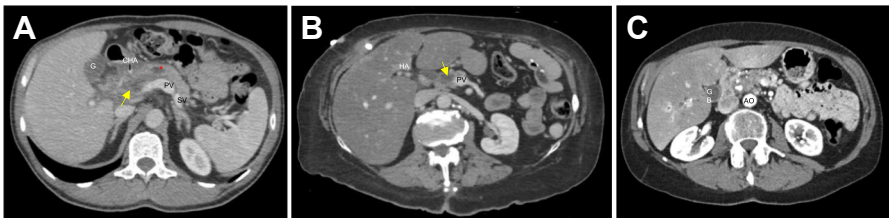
Examples of pancreas protocol CT scans of challenging diagnostic cases. (A) CP (mass-forming) at the head of the pancreas (yellow arrow) with main pancreatic duct dilation (asterisk); (B) PDAC in the head of the pancreas (yellow arrow) surrounding the portal vein; (C) CP and PDAC at the head of the pancreas with multiple calcifications and an irregular main pancreatic duct. AO, aorta; CHA, common hepatic artery; GB, gallbladder; HA, hepatic artery; PV, portal vein; SV, splenic vein.
